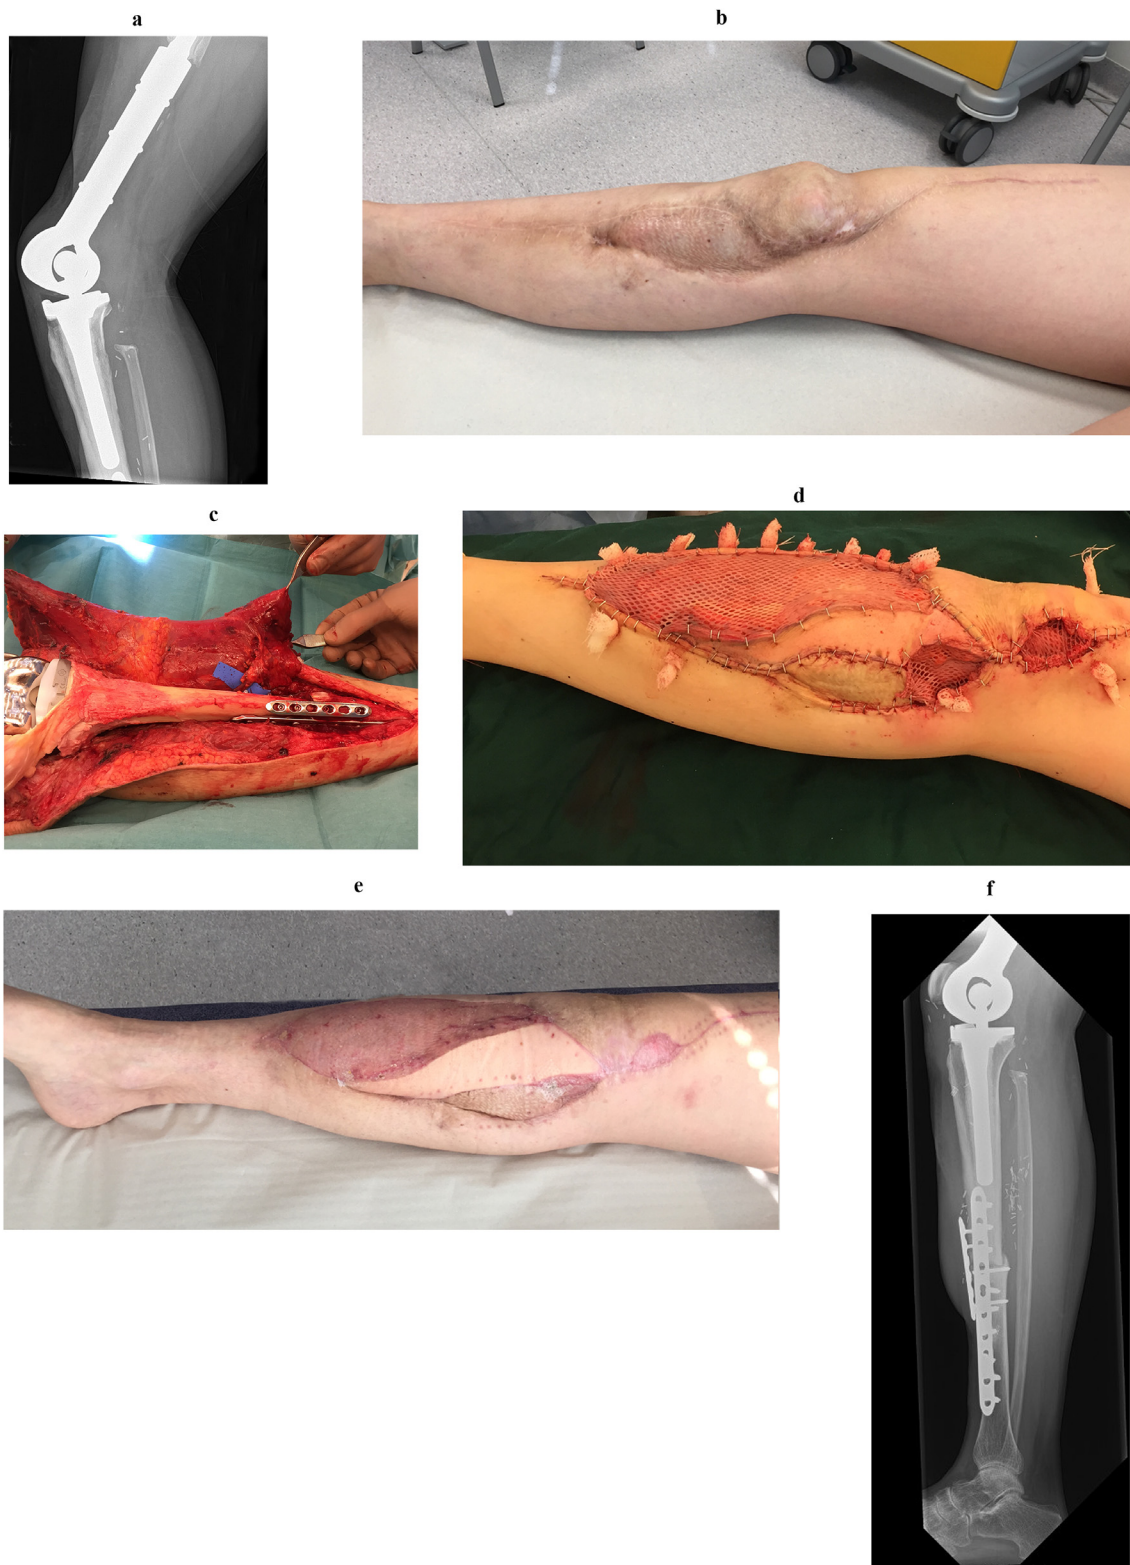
(a) A 40-year-old patient, who had osteosarcoma of the distal femur with proximal tibia skip-metastasis resected 20 years ago. Proximal tibia allograft and distal femur endoprosthesis were used for reconstruction. Patient developed chronic infection after revision surgery that resulted in resorption of allograft patella and loss of active knee extension. (b) Thin skin envelope over resorbed patella and previously used medial gastrocnemius flap and skin graft. (c) Patient underwent one-stage revision with new allograft and endoprosthesis. Endoprosthesis was covered with microvascular latissimus dorsi musculocutaneous flap. (d) Immediate post-operative result. The muscle flap reaches from allograft tibia junction to proximal over the patella. (e) Post-operative result at 6 weeks. (f) Post-operative X-ray at 13 months. Active range of motion is 0 to 60°.
